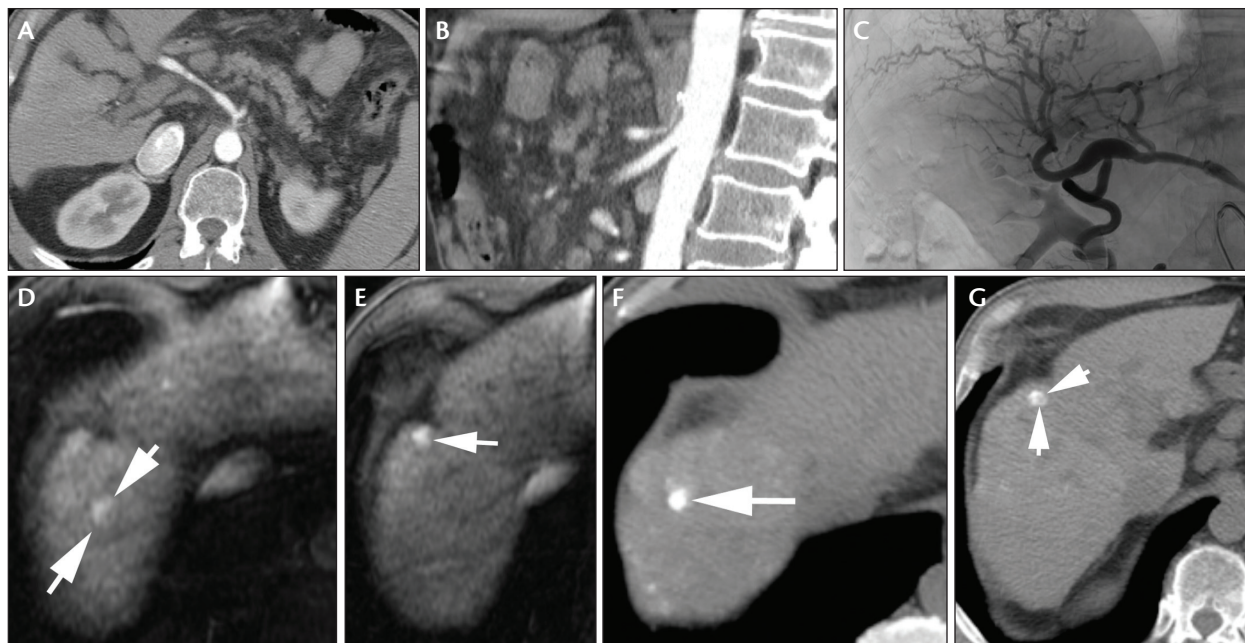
Axial (A) and sagittal (B) contrast-enhanced CT demonstrated near occlusion of the proximal celiac artery. The PDA branch of the SMA was selectively catheterized using a triaxial system, demonstrating a robust PDA, which allowed retrograde filling of the hepatic arteries (C). Axial MRI images before treatment demonstrated two LI-RAD category 5, segment 8 lesions (D, E). Axial noncontrast-enhanced posttreatment CT images demonstrated ethiodized oil uptake in the two treated lesions (F, G).
